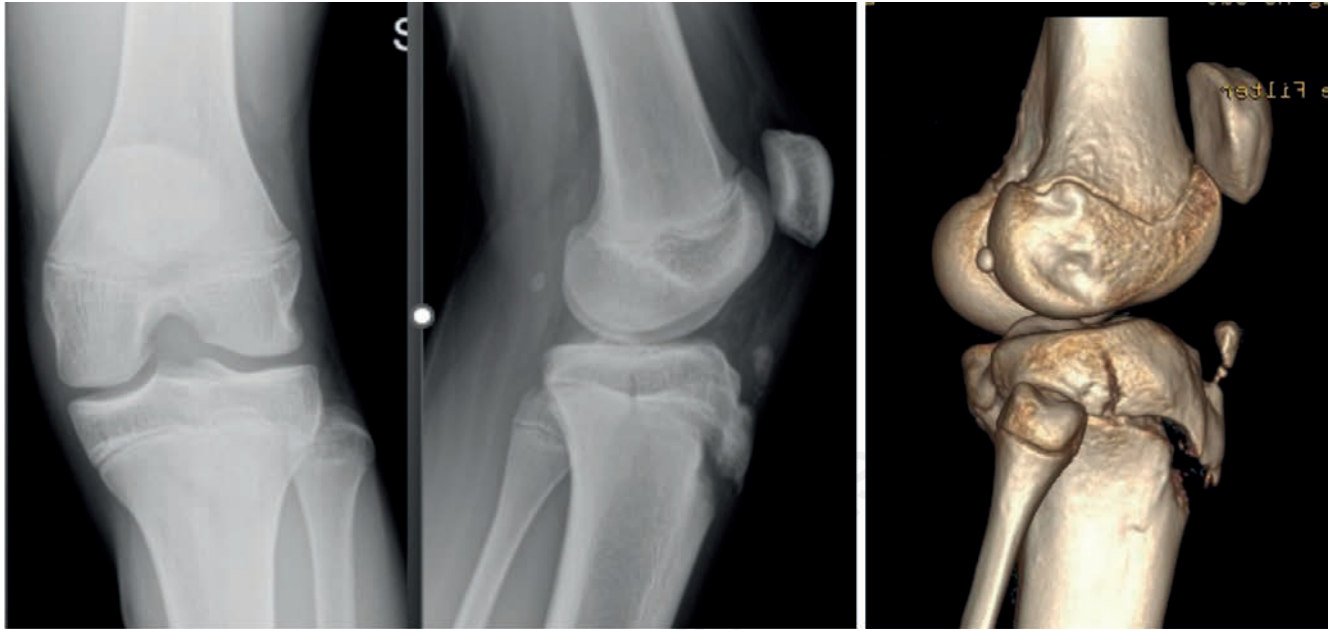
AP (left) and lateral (middle) radiographs showing displaced tibial tubercle fracture with extension to the intra-articular surface (Ogden IIIA). A 3D-CT scan (right).
